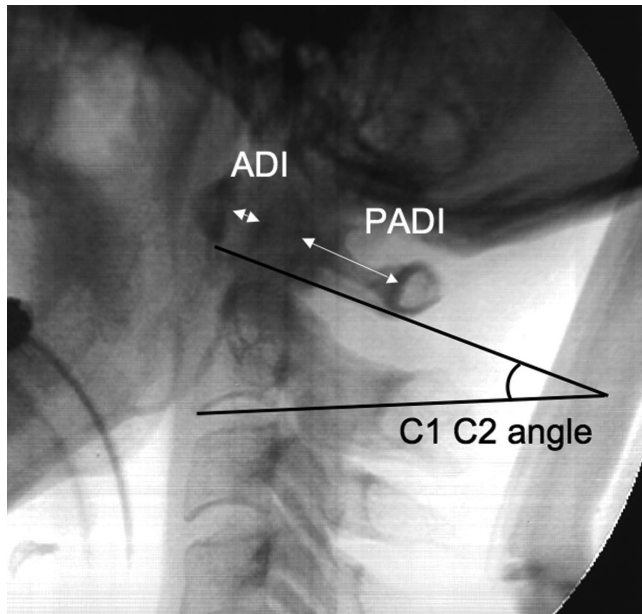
Measurements on lateral cervical radiographs. ADI = anterior atlantodental intervals; C1-C2 angle = angle between distal line of C1 and C2; PADI = posterior atlantodental interval.
